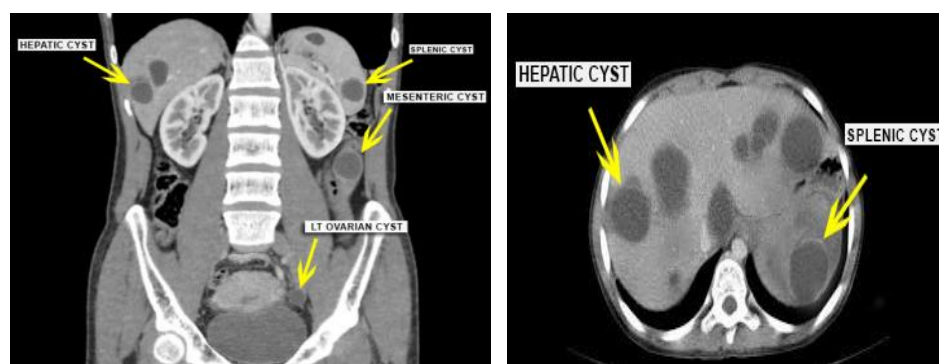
Coronal and axial CT images revealed hydatid cysts in different abdominal organs.
